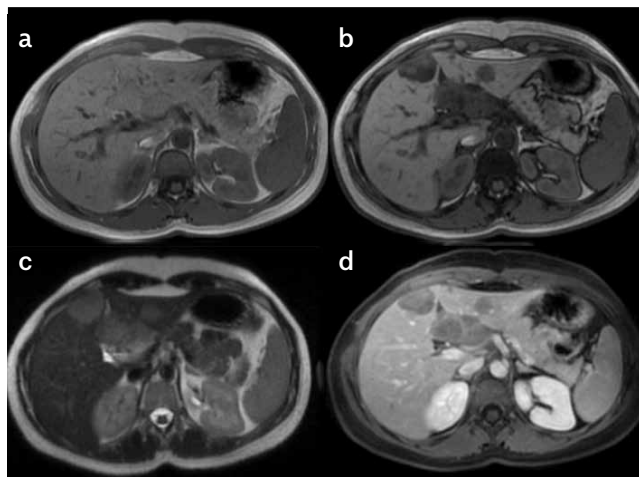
a-d. Axial contrast-enhanced liver MRI images Multiple isointense lesions on in-phase image (a); showing marked signal loss on out-of-phase image (b); Lesions are hyperintense on T2-WI (c); hypointense on postcontrast venous phase FS T1-W (d) images, and slowly enhancing after intravenous contrast administration
